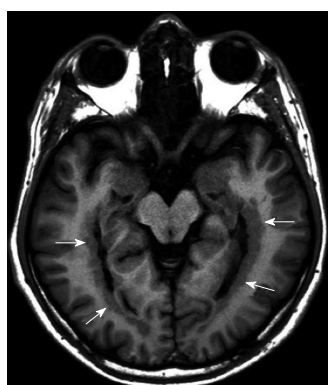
An 18-year-old boy with subependymal heterotopia. Axial inversion recovery T1-weighted image shows gray matter nodules located adjacent to bilateral periventricular temporal horn region (arrows).
